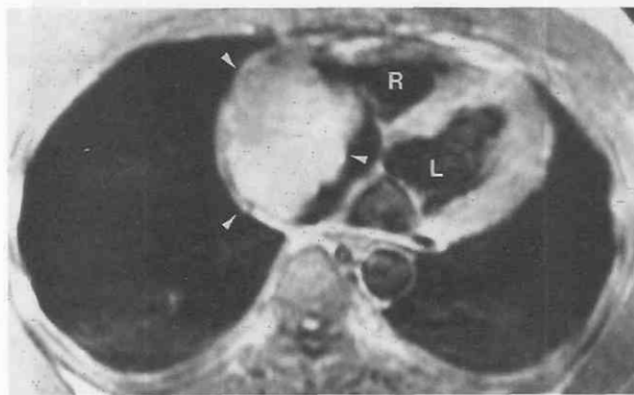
Non-Hodgkin's lymphoma with intracardiac involvement. Axial T1-weighted MR image shows a mass of heterogeneous signal intensity extending into right atrium (arrowheads). MRI allows assessment of intravascular and intracardiac tumor extension without administration of intravenous contrast material. L, left ventricle; R, right ventricle. (Reprinted with permission from Erasmus JJ, McAdams HP, Donnelly LF, Spritzer CE: MR imaging of mediastinal masses. *Magn Reson Imaging Clin North Am* 8:59-89, 2000.)
